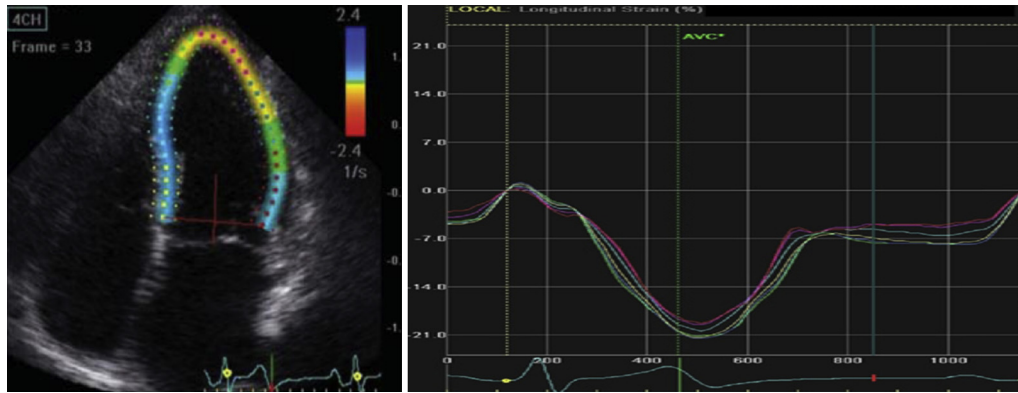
Apical 4 chambers longitudinal strain curves in a healthy subject.
